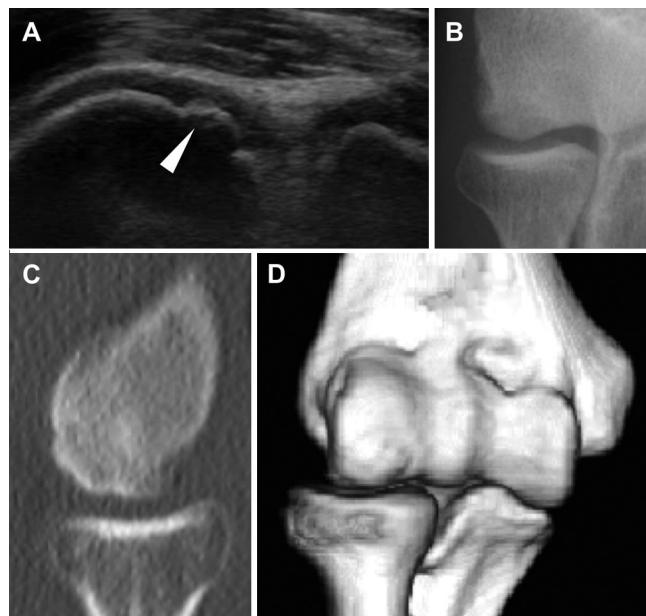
Stage IV (residual stage) osteochondritis dissecans of the humeral capitellum (irregular capitellum with no dissociation or loose bodies after closed epiphyseal line). (A) Ultrasonographic image obtained during the initial screening (anterior long-axis view). Irregularity of the subchondral bone was observed on the capitellum (arrowhead). (B) Radiograph (45° flexed tangential anteroposterior view) obtained at the initial examination. (C) Sagittal slice of humeral capitellum by computed tomography. (D) Anterior view of the 3-dimensional computed tomography.
